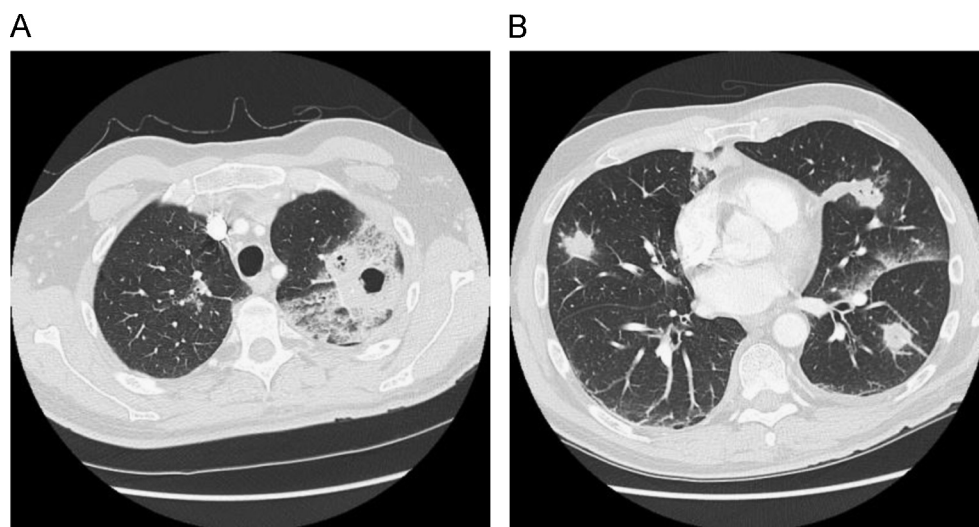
A. CT scan (with intravenous contrast) image of upper lobes of the lungs demonstrating an extensive area of consolidation of the apical-posterior segment of the left upper lobe with a large area of central cavitation. B. CT scan image of the lower lobes of the lungs showing numerous smaller foci of consolidation throughout the lungs bilaterally (18 nodular lesions in both lungs), some with central necrosis and some with central cavitation.
